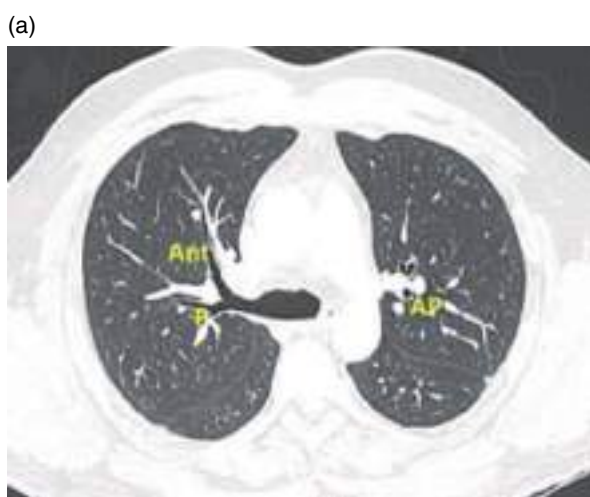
(a) Axial CT image (lung window). Right upper lobe bronchus and apicoposterior segment bronchus of the left upper lobe. Ant, anterior; P, posterior; AP, antero-posterior. (b) Axial CT image (mediastinal window). AT, anterior trunk; SPV, superior pulmonary vein; AS, anterior segment artery; LPA, left pulmonary artery.
